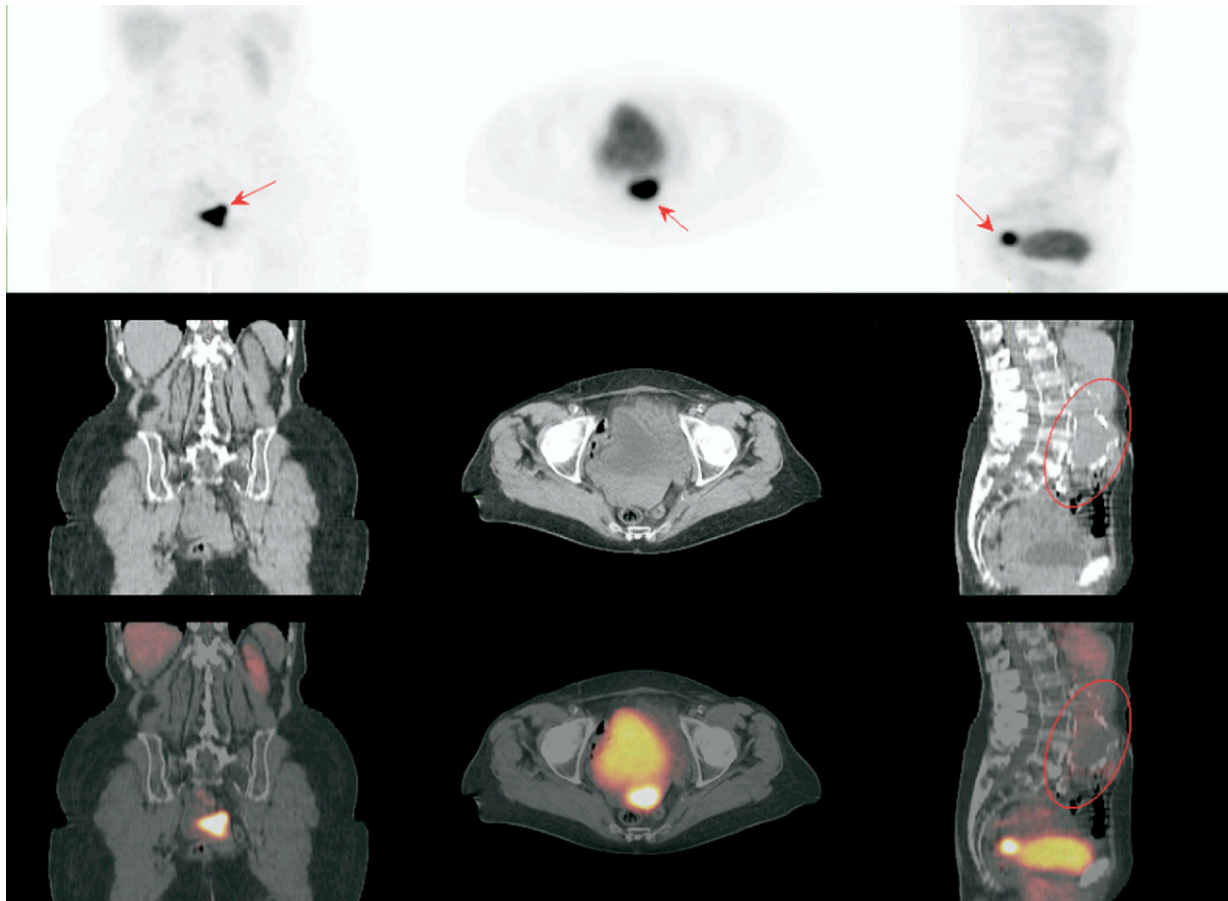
Incidental finding of endometrial carcinoma (*arrow*) in a patient scheduled for aneurysm repair. The top row shows the PET image. The abdominal aortic aneurysm is visible on the CT (*middle row*) and fused image (*bottom row*) on the right (*red circle*). PET, Positron emission tomography; CT, computed tomography.
